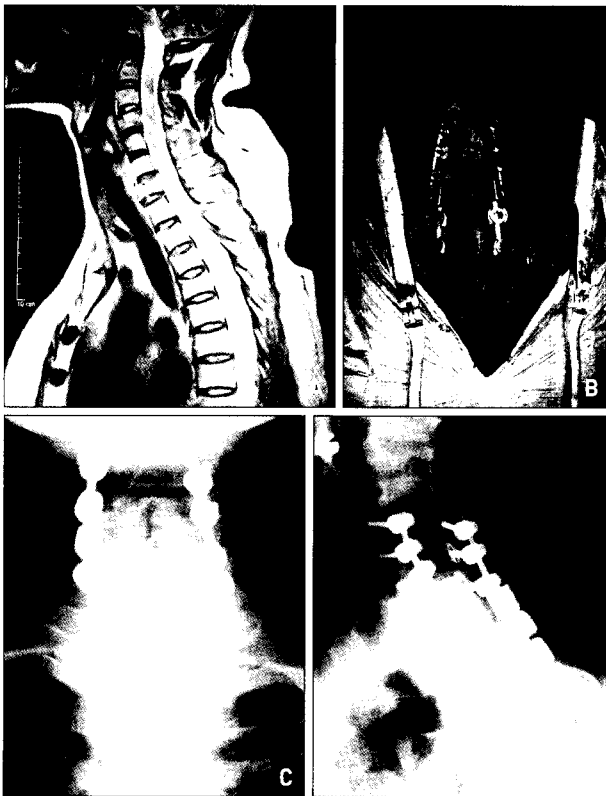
Case 2. Sagittal T2-weighted magnetic resonance image (A) of the cervical spine shows dislocation of C7 on T1 and spinal cord compression. Chest computed tomography (B) demonstrates severe hemothorax. Postoperative anteroposterior cervical spine radiograph (C) shows posterior instrumentation.
